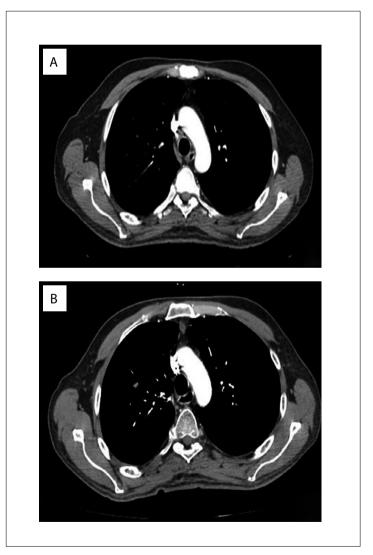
A) Computed tomography (CT) scan after neoadjuvant chemotherapy, showing that the tumor had almost completely regressed. B) CT scan showing absence of recurrence three months after surgery.
